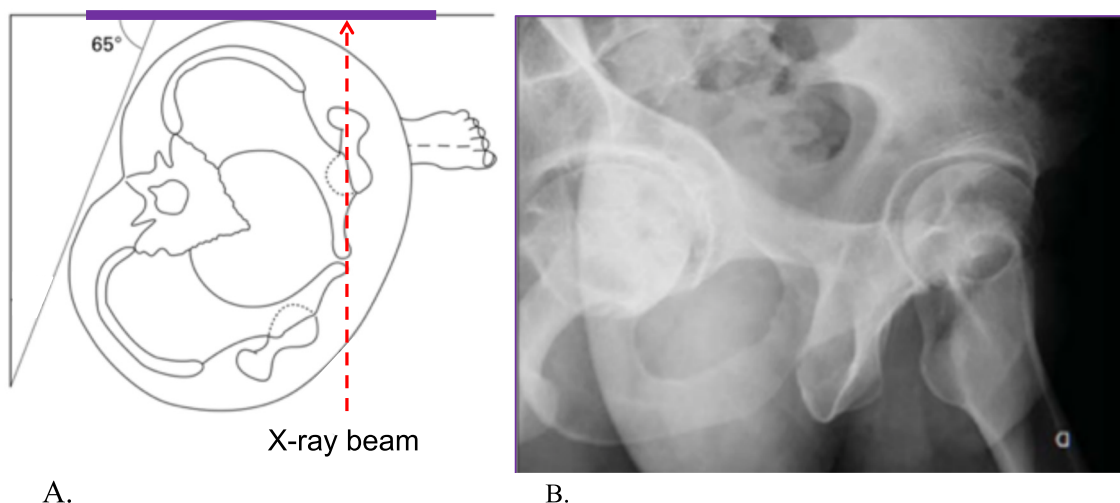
Standing oblique (false profile of Lequesne) view. With the subject turned 65° towards the index hip, the parallel X-ray beam is centered on the femoral head (A). The resulting image should project the two hips the diameter of a femoral head apart from each other (B).
